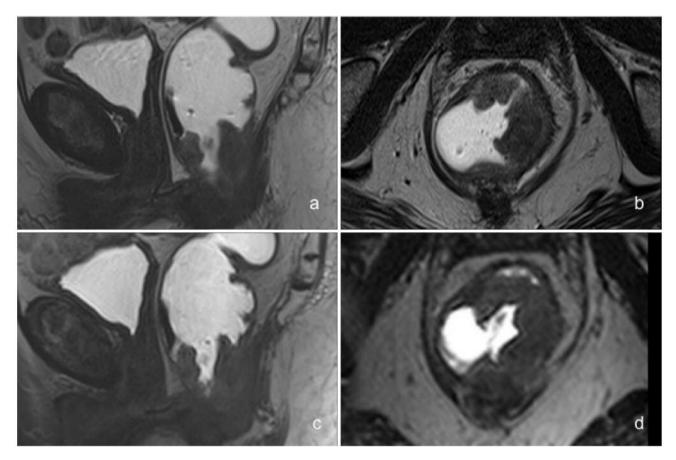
Imaging of primary rectal cancer (T3) in a 73-year-old man. a: 2D Sagittal T2-weighted sequence (T2WI); b: 2D axial 2WI. c: 3D sagittal T2WI. d: reformatted axial image of 3D T2WI. The delineation of tumor is superior on 2D T2WI.
